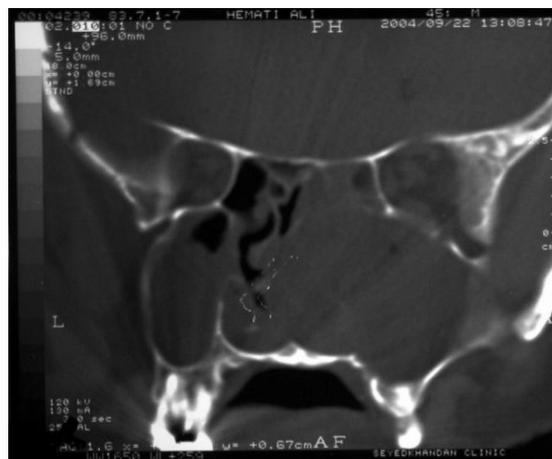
CT scans of the paranasal sinuses showing a large soft tissue density in right maxillary sinus protrude to right nasal cavity and destruction of medial wall of right maxillary sinus and extension to nasopharynx is seen.
